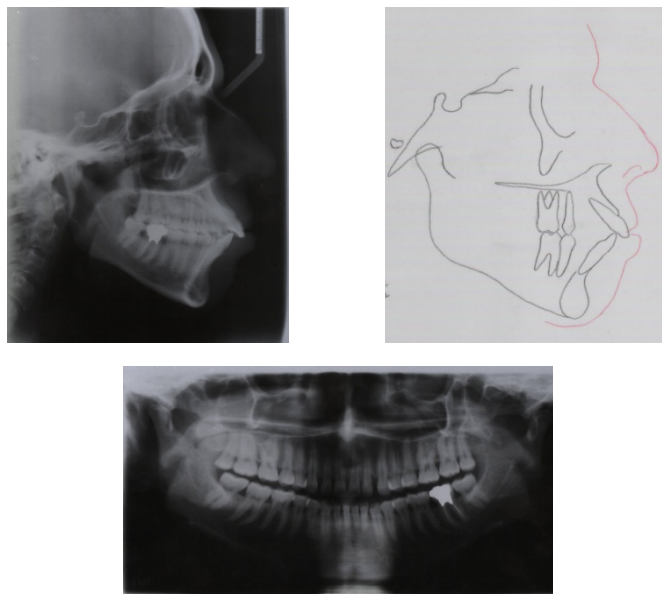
Figs 19-a to 19-c, pretreatment cephalogram, cephalometric tracing and panoramic radiographic.
